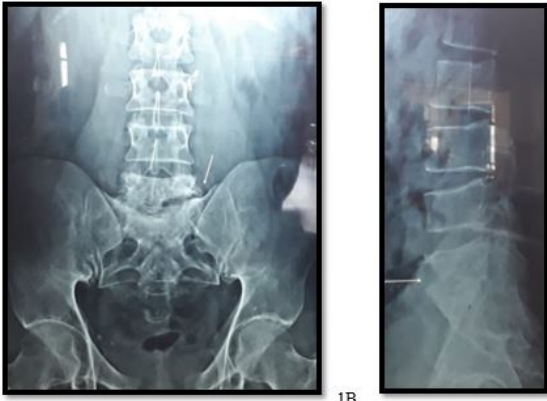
Digital X-ray showing Lumbar spine anteroposterior view(1A) and lat view(1B). X-ray showing involvement of L5 and S1 vertebrae with loss of vertebral height.
